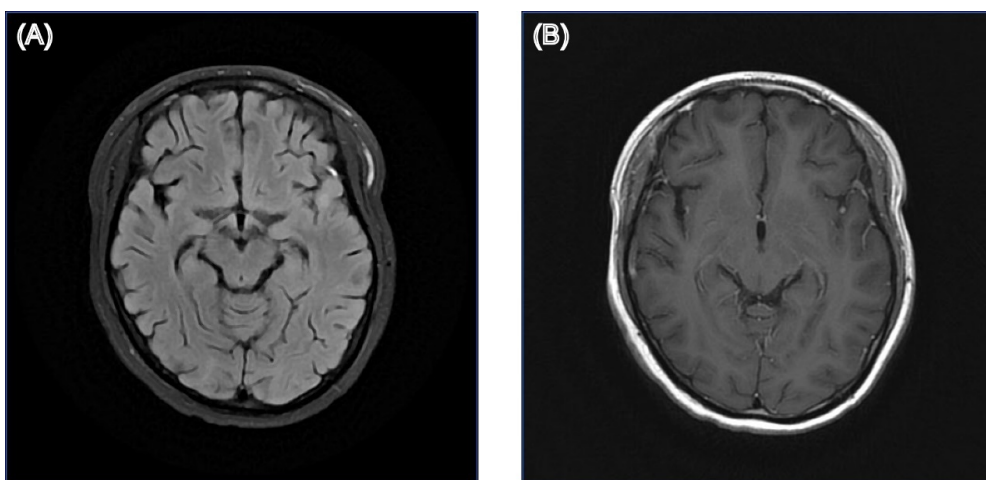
Structural brain MRI images of patient 01. (A) T2-weighted fluid-attenuated inversion recovery (T2-FLAIR) image; (B) Gadolinium-enhanced T1-weighted (Gd-T1w) image.
